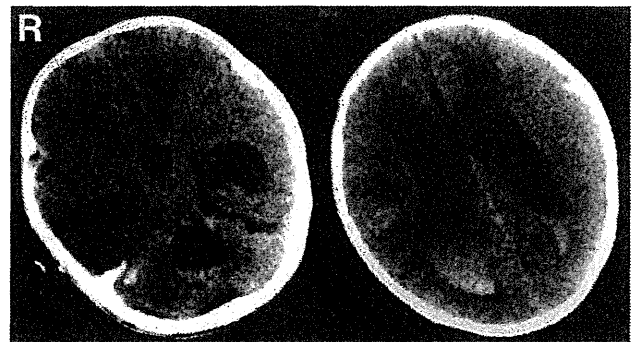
Case 1. Preoperative computed tomography scans showing intraventricular, left parietal intracortical hemorrhage, and communicating hydrocephalus.
